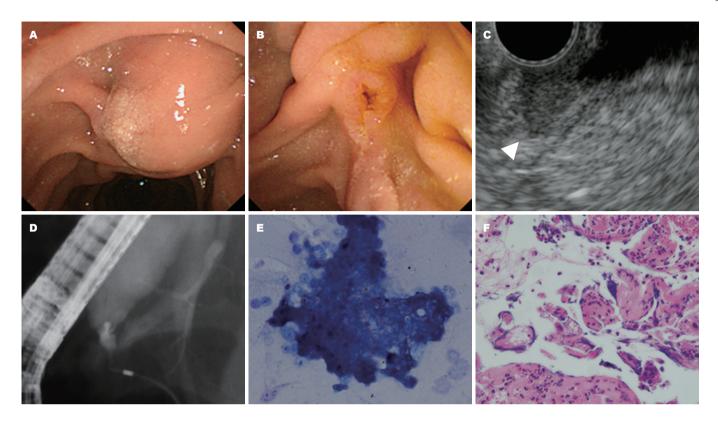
Endoscopic findings showed swelling of the ampulla of Vater (Fig. 2A, B). Endoscopic ultrasound showed a low echoic mass extending to the common bile duct (CBD), and the distal part of the CBD was stenosed by ERCP (Fig. 2C, D). Brush cytology and biopsy showed no malignancy (Fig. 2D, E).
